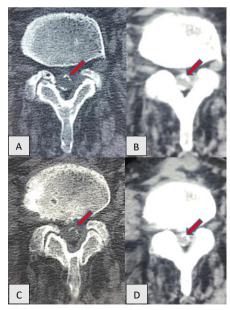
(*A*-D) Lumbosacral CT: axial scans with algorithms for both bone and parenchyma: calcific epiduritis (arrows).
